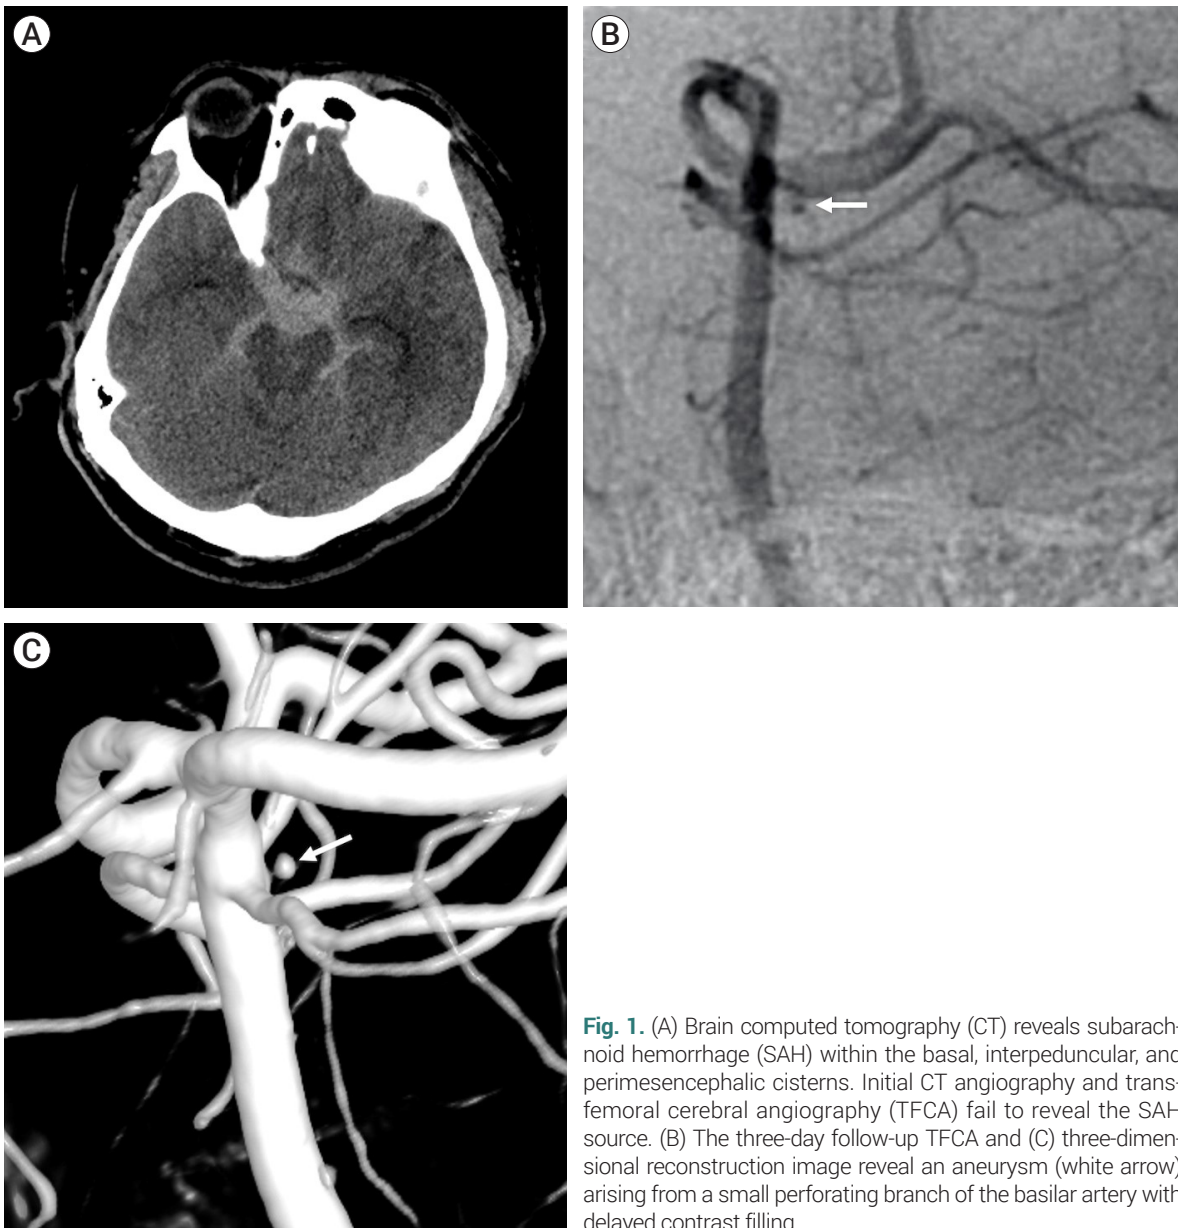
(A) Brain computed tomography (CT) reveals subarachnoid hemorrhage (SAH) within the basal, interpeduncular, and perimesencephalic cisterns. Initial CT angiography and transfemoral cerebral angiography (TFCA) fail to reveal the SAH source. (B) The three-day follow-up TFCA and (C) three-dimensional reconstruction image reveal an aneurysm (white arrow) arising from a small perforating branch of the basilar artery with delayed contrast filling.
